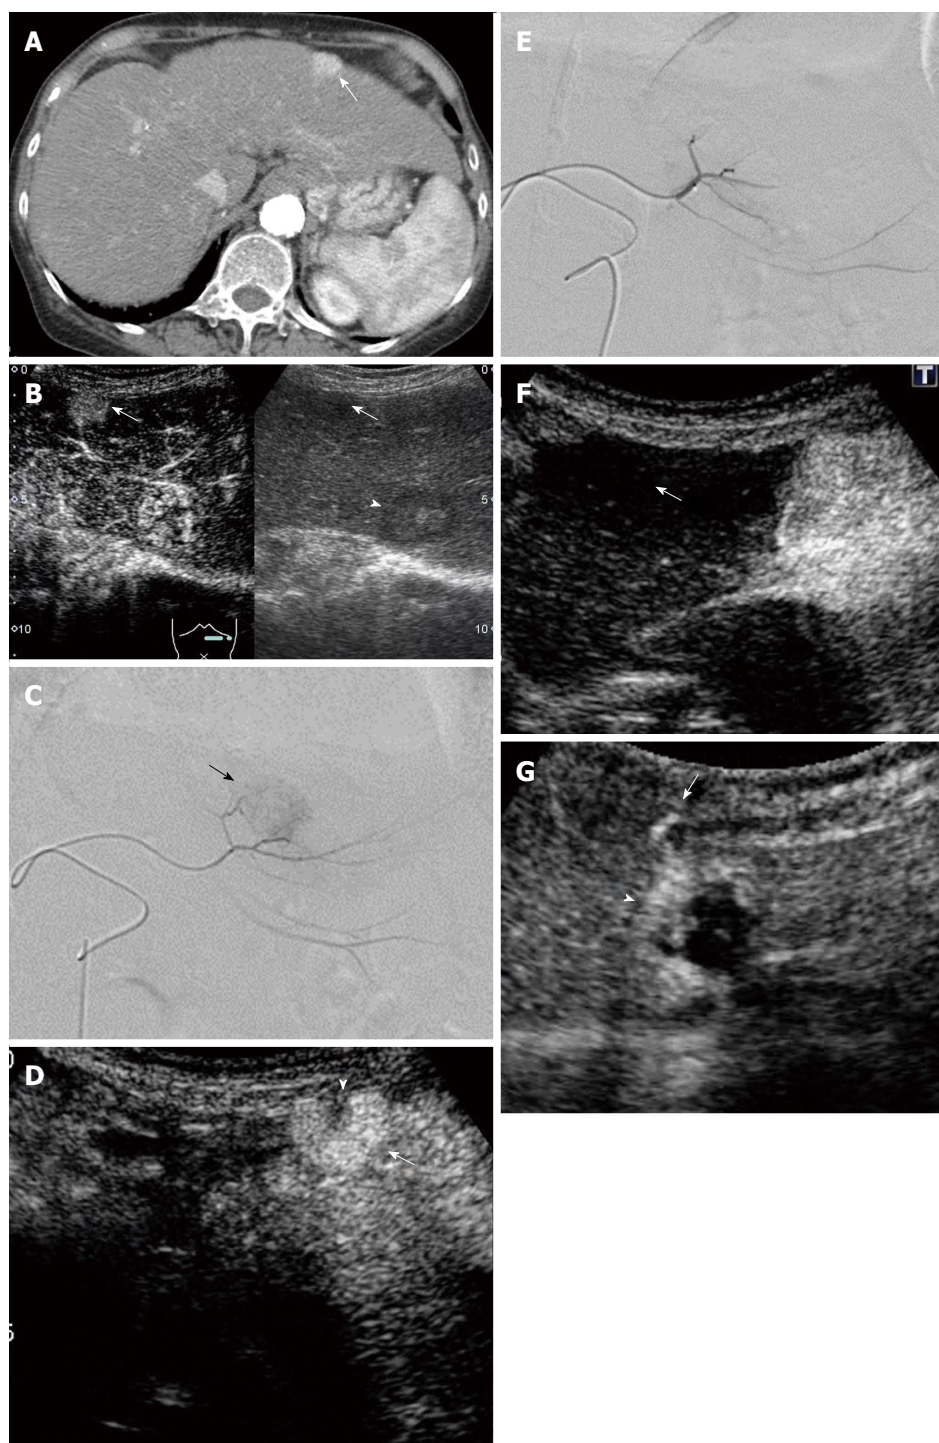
The patient was a 76-year-old female with hepatitis C virus cirrhosis. DEB-TACE and IAUS for HCC in S3 with a diameter of 17 mm were performed. A: Dynamic CT in the arterial phase before DEB-TACE showed a hypervascular lesion in S3 (arrow); B: CEUS in the arterial phase before DEB-TACE showed a hyperenhanced lesion in S3 (arrow) and S2 (arrow head). Radiofrequency ablation was performed for the lesion in S3 after DEB-TACE (Right image: monitor mode); C: DSA from A3 before DEB-TACE showed tumor enhancement (arrow); D: IAUS from A3 before DEB-TACE showed a hyperenhanced lesion (arrow) with a small hypoenhanced area (arrow head), which was not recognized during the procedure. This small hypoenhanced area was recognized with stored video images after DEB-TACE procedure; E: DSA from A3 after DEB-TACE (when contrast medium disappeared from the blood vessel within 5-6 heart beats) eliminated the tumor enhancement; F: The enhanced lesion was disappeared by IAUS from A3 after DEB-TACE (arrow); G: CEUS showed enhancement area in the tumor (arrow head) and extrahepatic feeding artery (arrow) three days after DEB-TACE. It was thought this artery fed the small hypoenhanced area.
